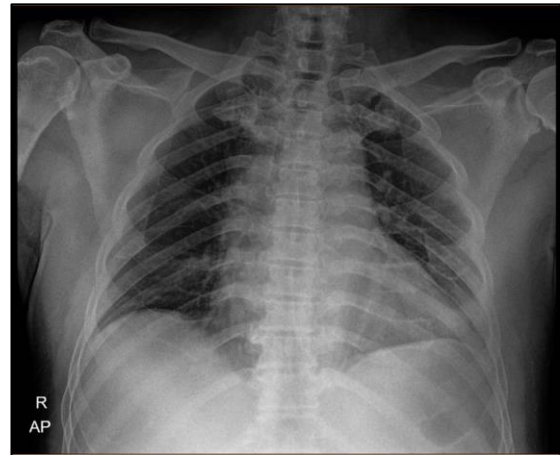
Chest X-ray result.
